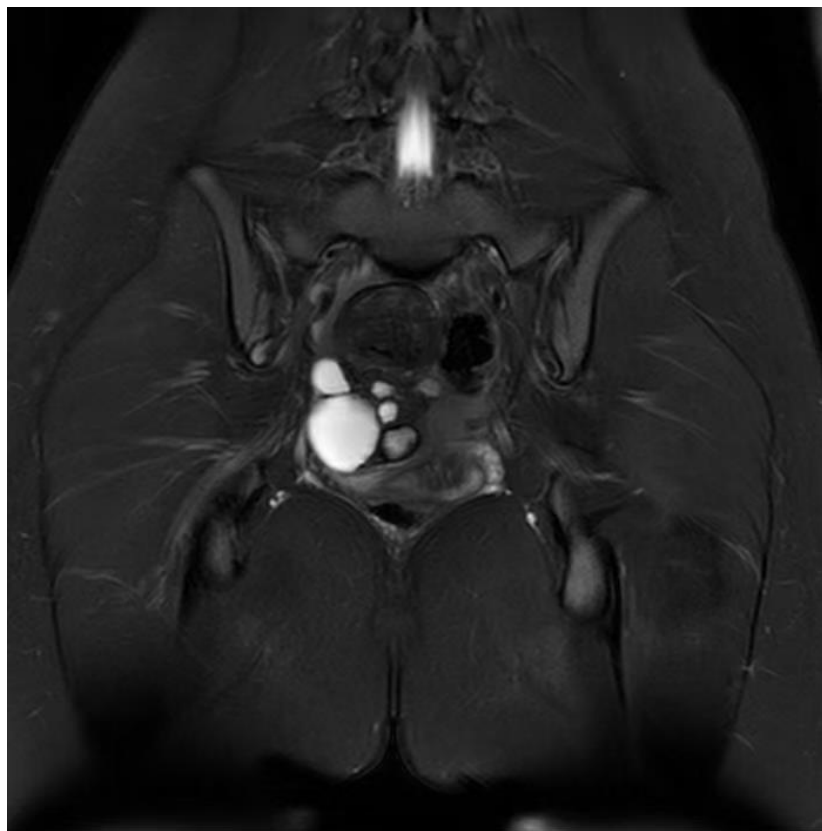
MRI scan of the pelvis showing the right ovary cystic ovary torsion lesion.
